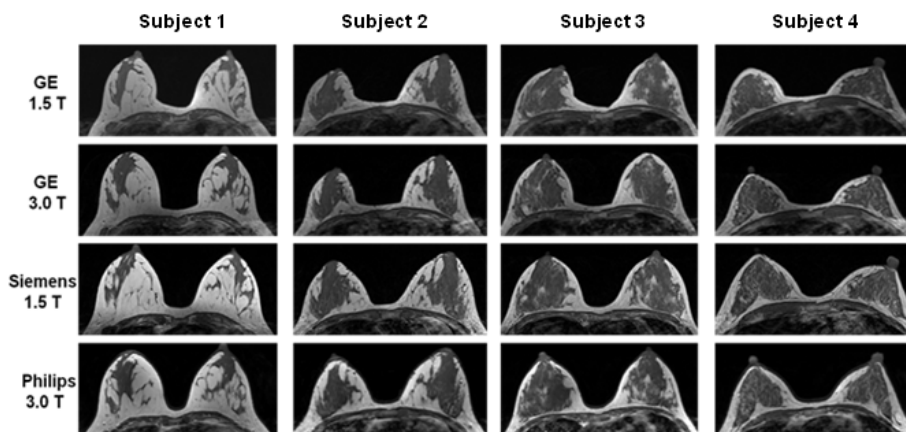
Representative images of breast MRI from four subjects acquired using four MR scanners. They present different amount of dense tissues and different breast parenchymal morphological patterns. The measurement of BV, FV, and PD are listed in Table 1. The coefficient of variation is in the range of 2%-9%.
